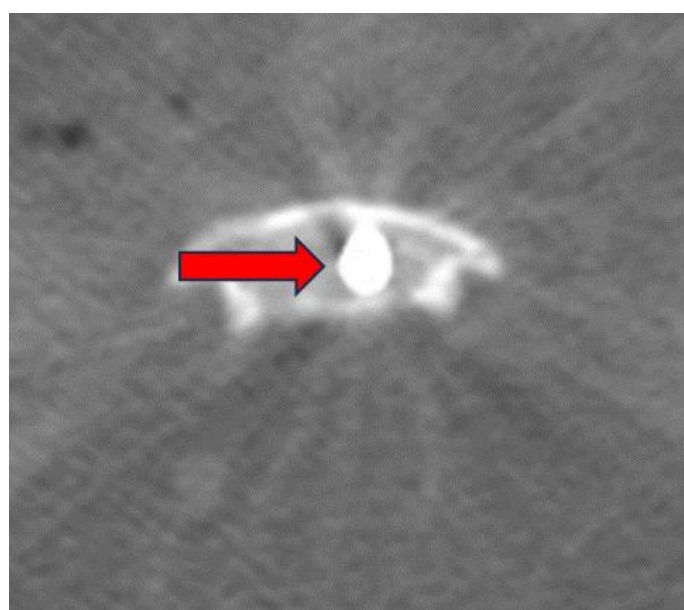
CT control axial view (arrow).*
